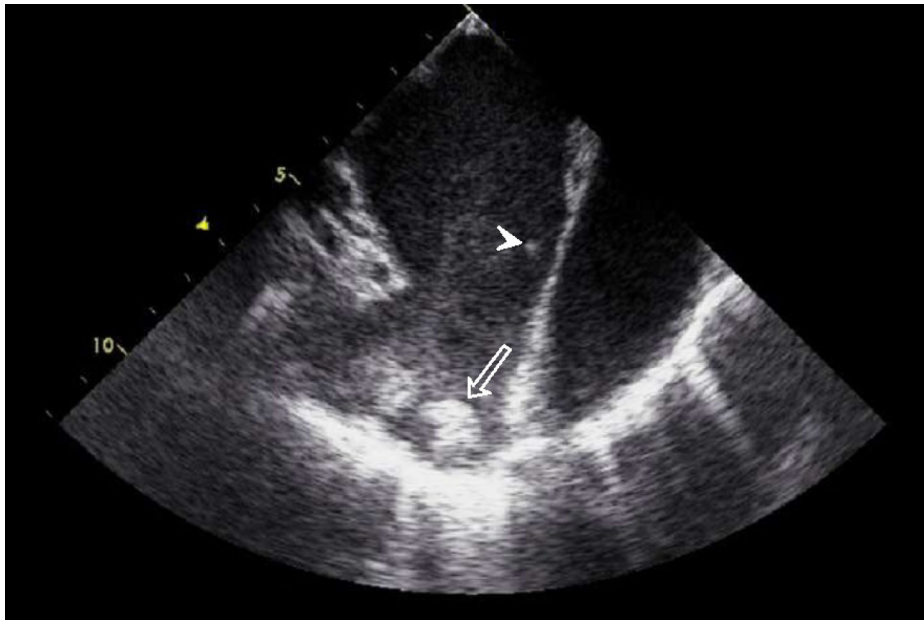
Transesophageal echocardiography demonstrating two left atrial thrombi (arrows) with ‘smoke.’
